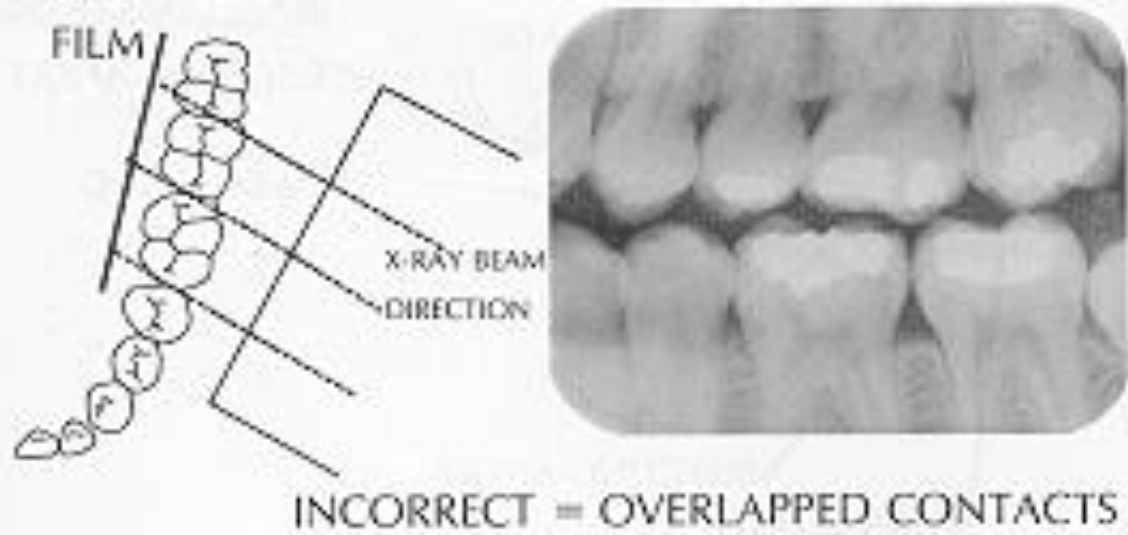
Incorrect and correct horizontal angulations and resultant radiographs.
